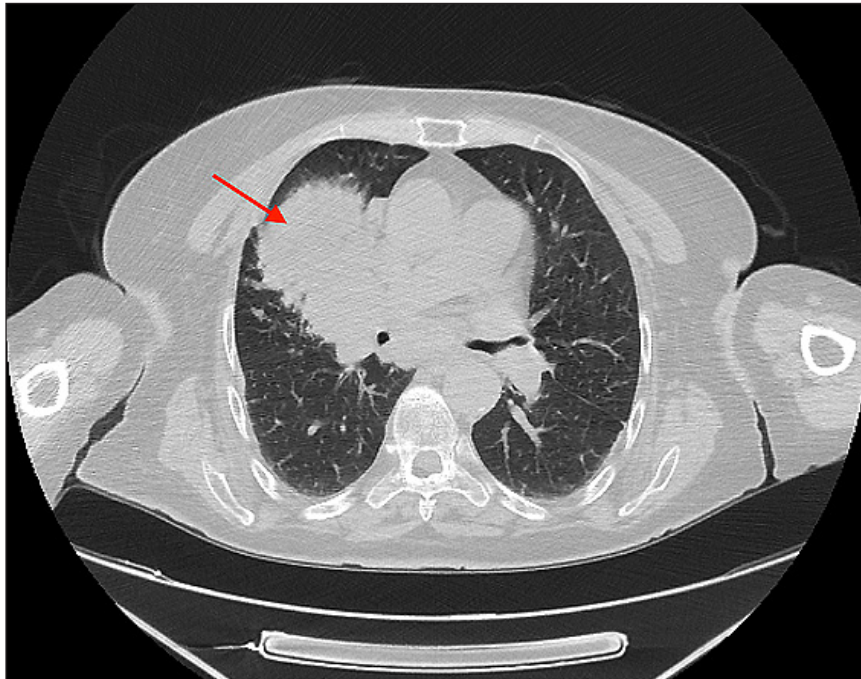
Thoracic computed tomography (CT) of Case 2. The arrow indicates the right hilar mass consistent with small-cell neuroendocrine carcinoma.
